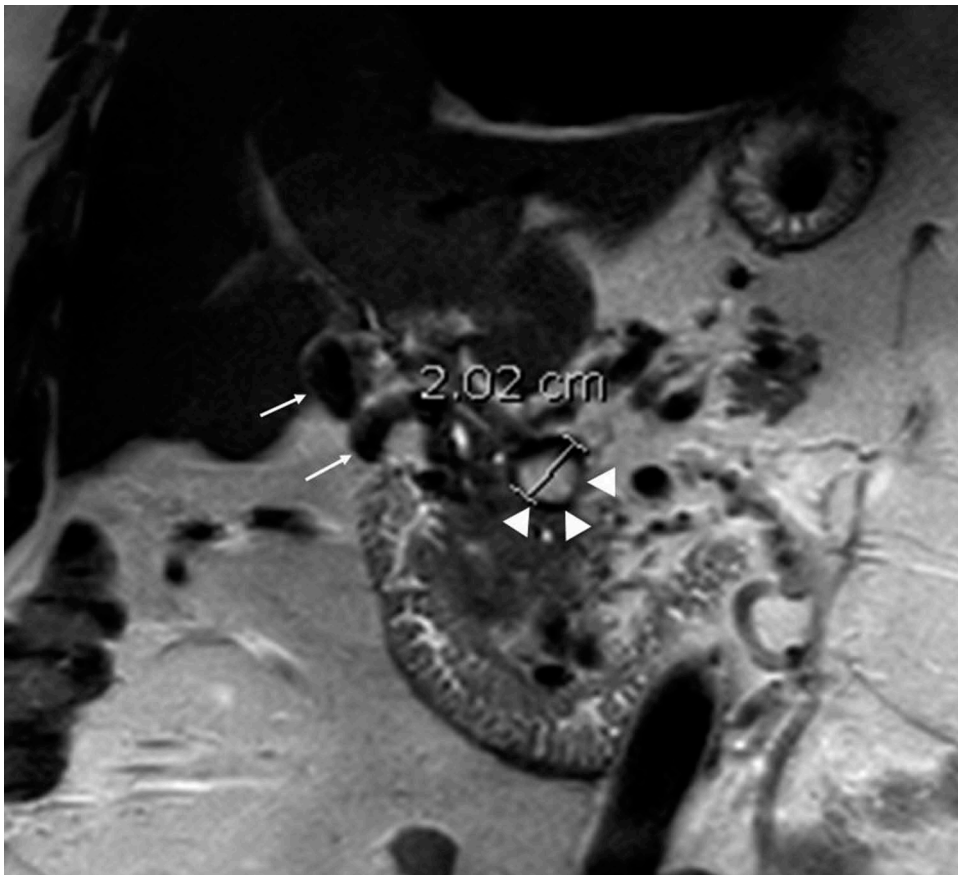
Coronal T2 weighted MR image (TE80 – TR995). Reduced diameter of the thrombosed confluence aneurysm to almost 2 cm (arrowheads), with T2 hyperintens lumen and T2 hypo-intens wall compatible with ageing blood. Portosystemic collaterals in the liver hilum (thin arrows). The pancreatic neuro-endocrine tumors are not depicted on this image.
